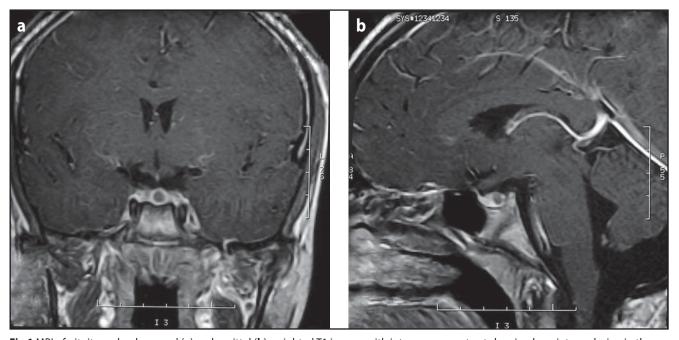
MRI of pituitary gland: coronal (a) and sagittal (b) weighted T1 images with intravenous contrast showing hypointense lesion in the posterior aspect of the pituitary gland measuring 4×5×2 mm.
